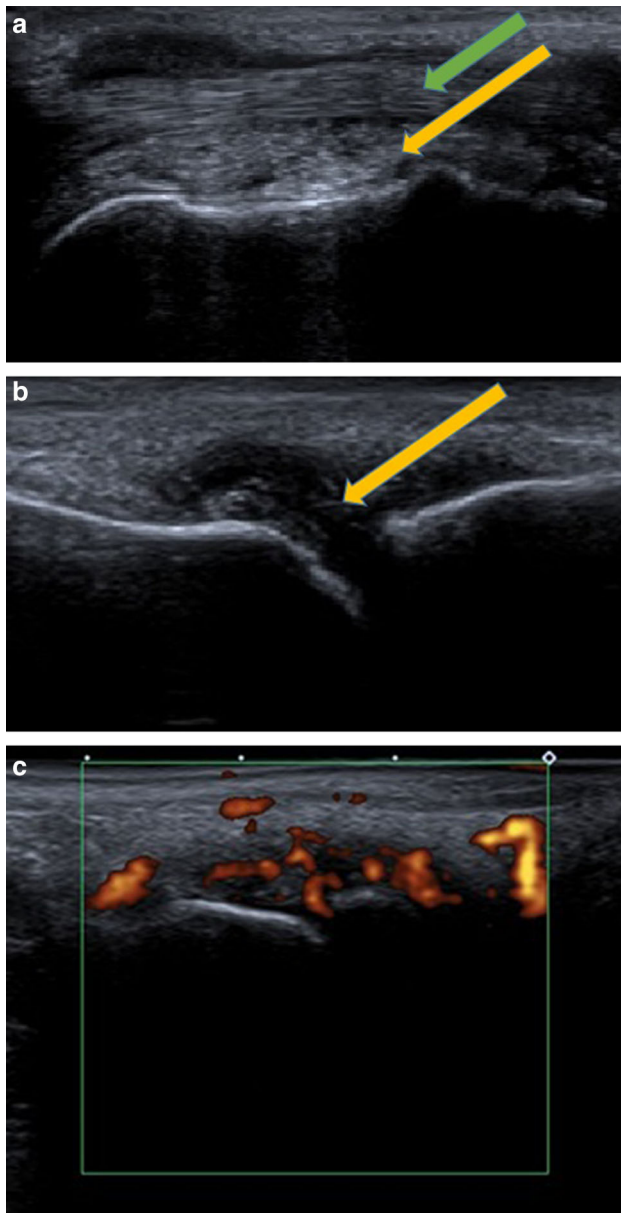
A 22-year-old female with Chikungunya fever who presented with 6 weeks of polyarthritis and low-grade fever. a Longitudinal ultrasound of the posterior tibial tendon (green arrow) demonstrates fluid and synovial proliferation (yellow arrow), indicating tenosynovitis associated with late stage Chikungunya fever. b Longitudinal ultrasound of the 3rd metatarsophalangeal joint demonstrates similar synovial proliferation (yellow arrow). c Power Doppler images show increased flow, indicating synovitis of the 4th metatarsophalangeal joint Images courtesy of Clarissa Canella, MD, Universidade Federal Fluminense, Rio De Janeiro, Brazil (Color figure online)
